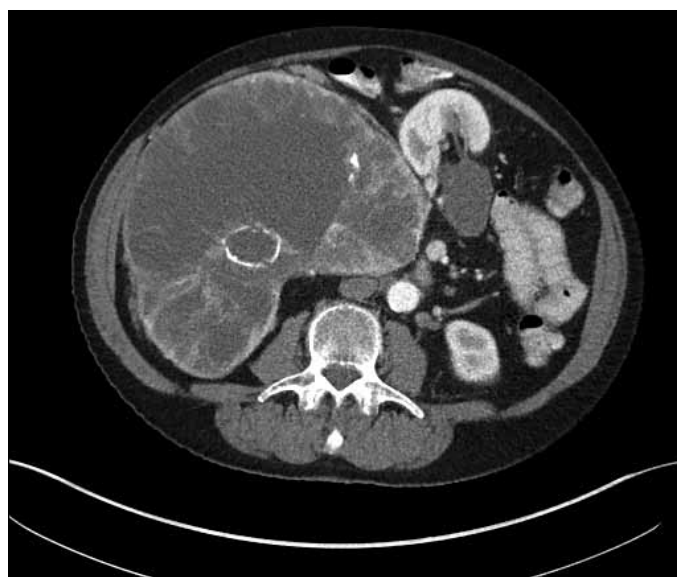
Large mass seen on computed tomography scan (axial section).
